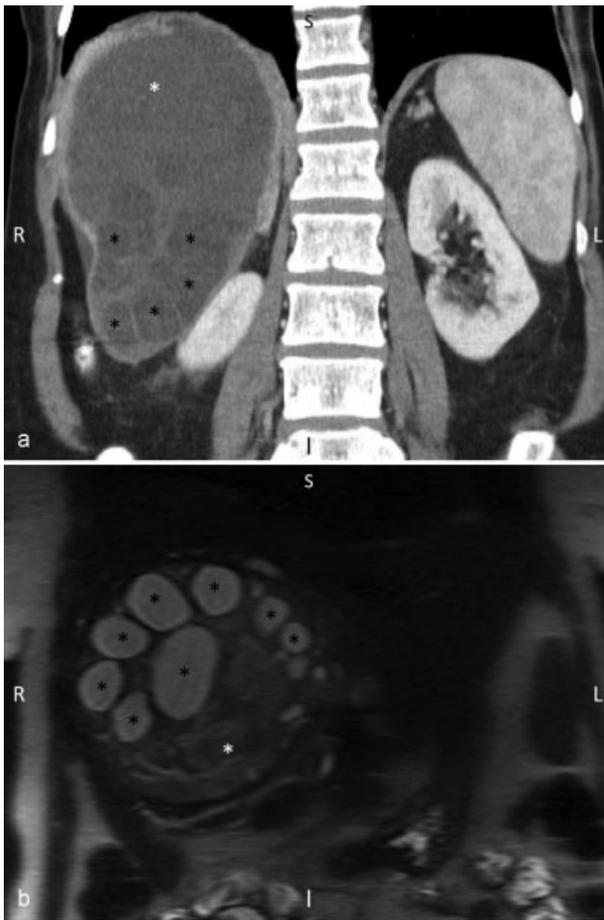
(a) Coronal contrast material-enhanced CT scan of the liver demonstrates multiple daughter cysts (black asterisks) within the primary *Echinococcus* liver cyst (white asterisk). (b) Coronal T2WI of the liver demonstrates multiple daughter cysts (black asterisks) within the primary *Echinococcus* liver cyst (white asterisk). CT, computed tomography; T2WI, T2-weighted imaging.
